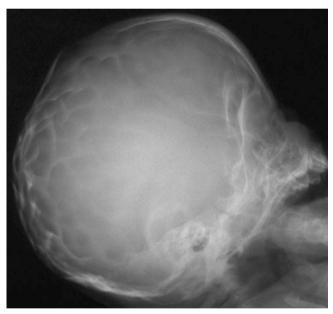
Picture of plain radiograph with copper beaten appearance
